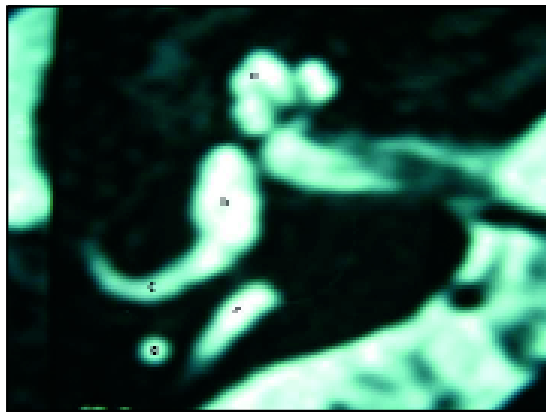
Magnetic resonance imaging in Case 1, axial section, T2-weighted sequence: dilation of the right endolymphatic canal (e). Visualization of the cochlea (a), utricle (b), horizontal semi-circular canal (c), and posterior semi-circular canal (d).
